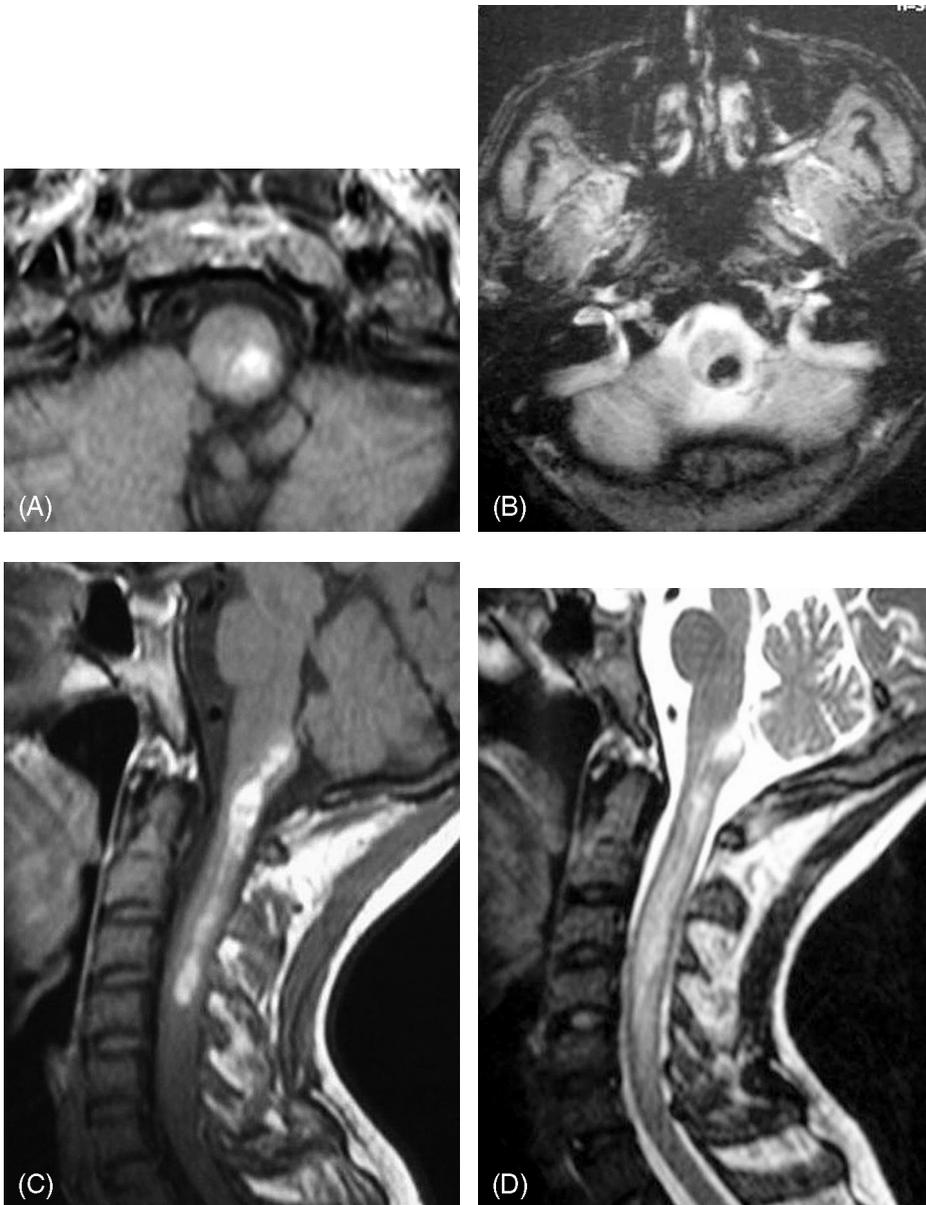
Thirty-four-year old man with history of familial Mediterranean fever (FMF), secondary amyloidosis, and hemorrhagic diathesis. (A and B) Axial T1- and gradient T2-weighted images. (C and D) Sagittal plane T1- and T2-weighted images obtained in the first and second weeks after quadriplegia following acute onset of neck pain. Delayed images show better intensity difference and display the actual extension of the intramedullary hematoma.
